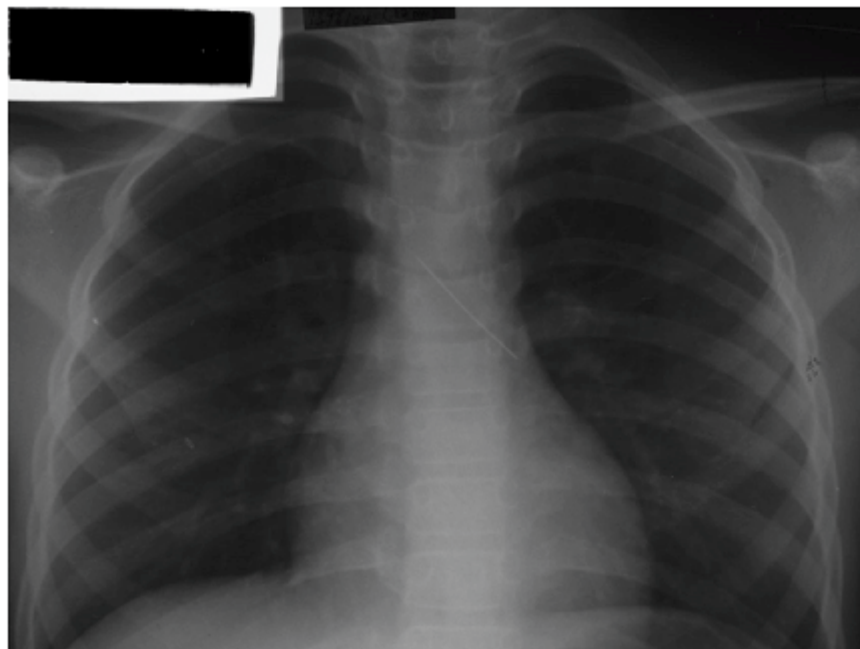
Final Chest Radiograph Revealing A Sudden Migration of the FB into the Left Bronchus. No Traumatic Injury or Lung Complications could be Identified Despite of Treatment Delay or FB Migration
